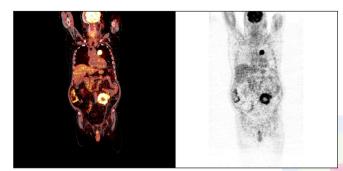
Local recurrence (SUVMax: 18) and mediastinal lymphadenopathy (SUVMax:18) in PET/CT imaging was determined 68-years-old male patient's survival was calculated as 350 days.
